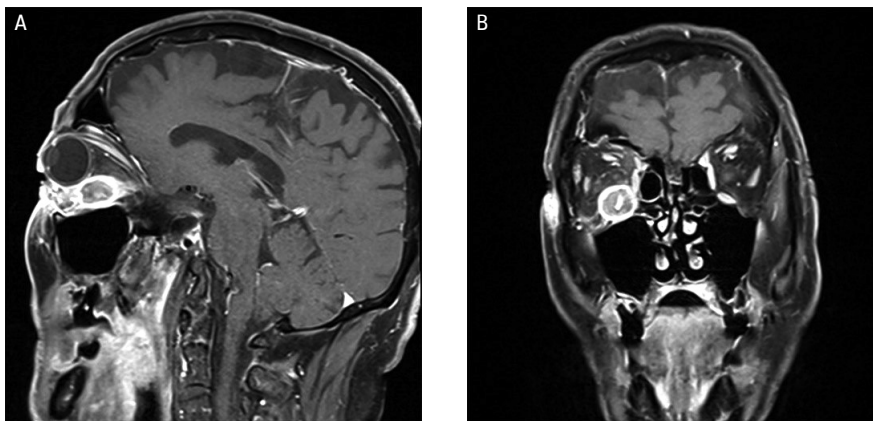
Magnetic resonance imaging of the orbits. A. Sagittal view of the extraocular tumour in the right orbit. B. Coronal view of the extraocular tumour in the right orbit
